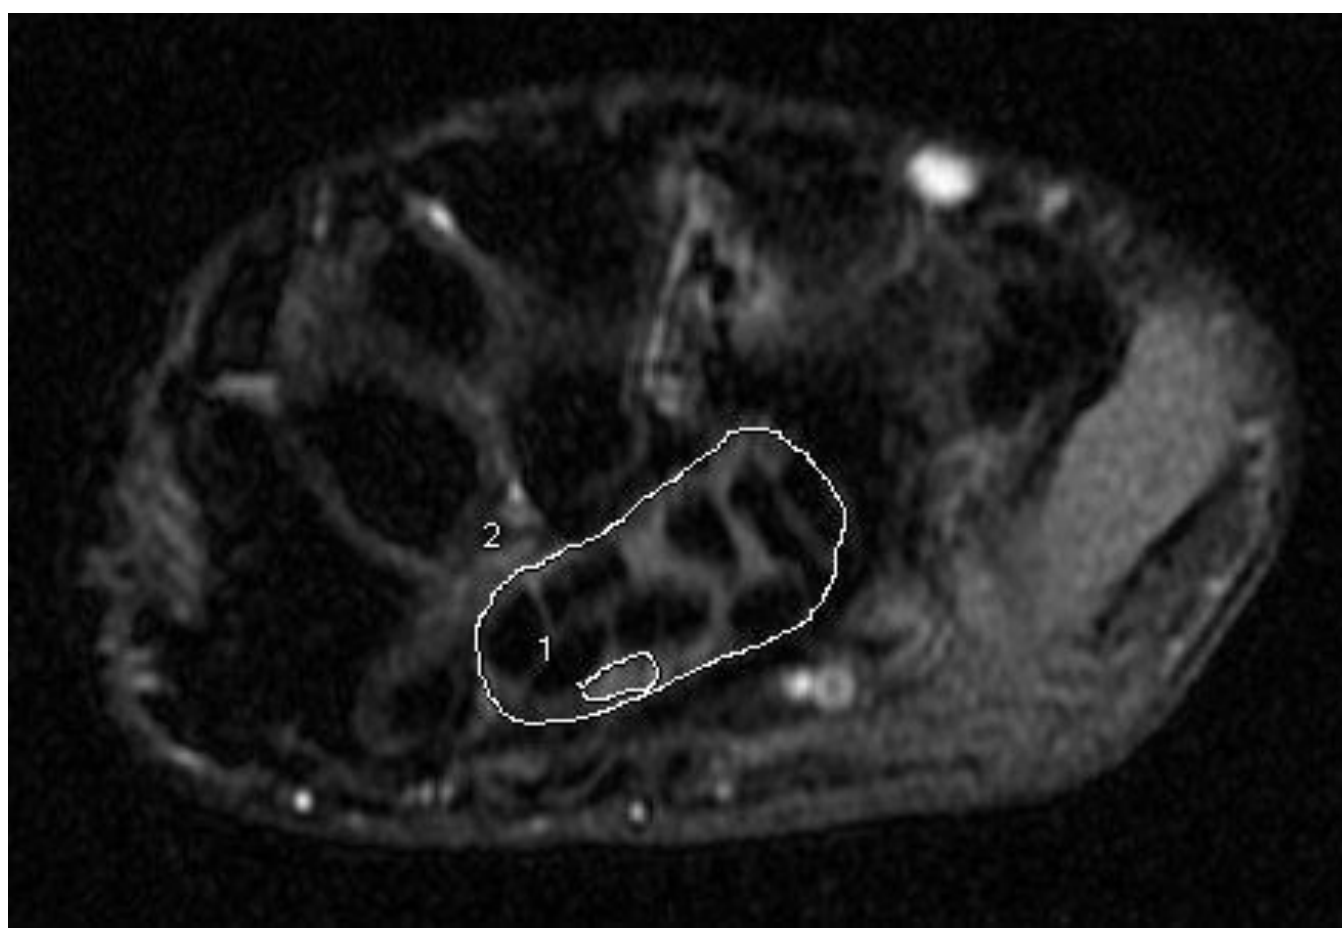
MRI of the wrist
